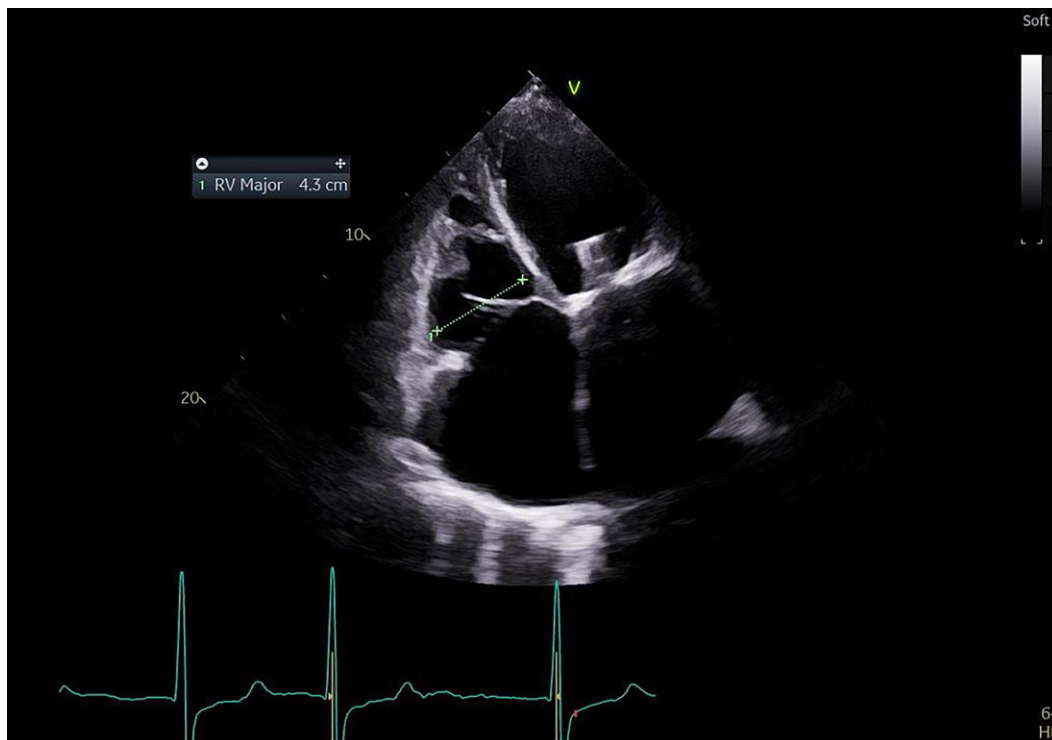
Transthoracic echocardiogram apical-4-chamber view showing reduction of right ventricle basal diameter from 5.2 to 4.3 cm within 3 months.
